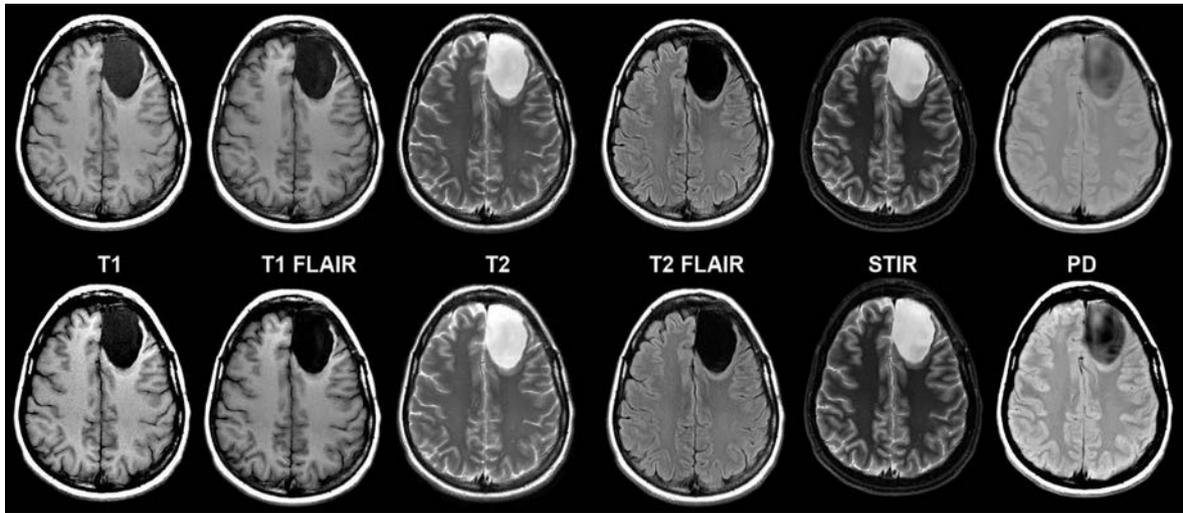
Left frontal lobe cystic tumor on axial synthetic and conventional 3T MR imaging in a 31-year-old woman. Conventional (*upper row*) and synthetic (*lower row*) image sets exhibit similar legibility and quality.
